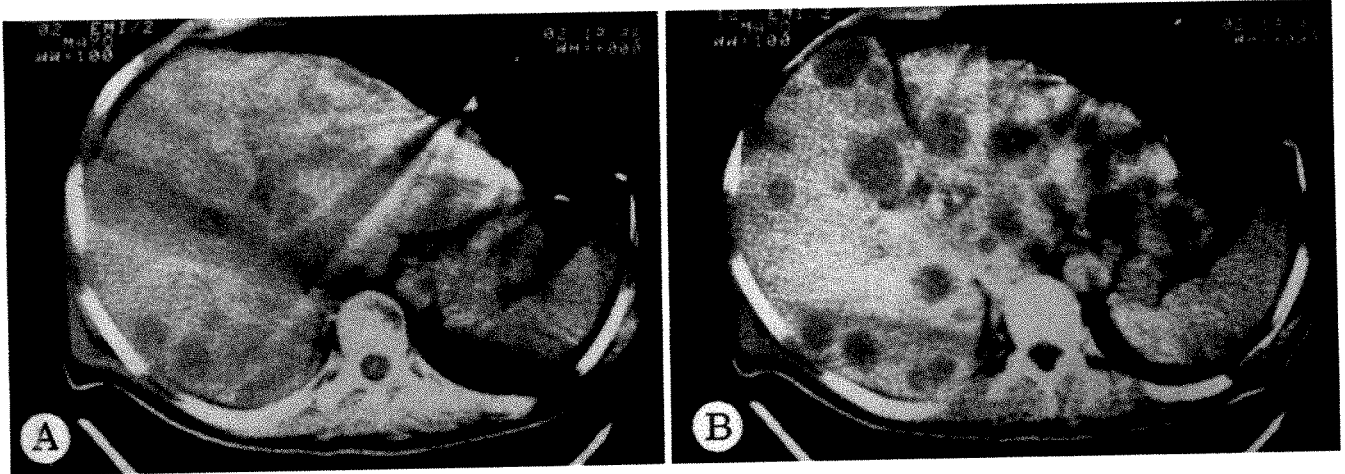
CT scans of 51-year-old man with loss of weight, back pain, and large supraclavicular lymph node. Biopsy of node revealed mucous adenocarcinoma. Hepatic metastases shown before (A) and after (B) contrast material given intravenously.
